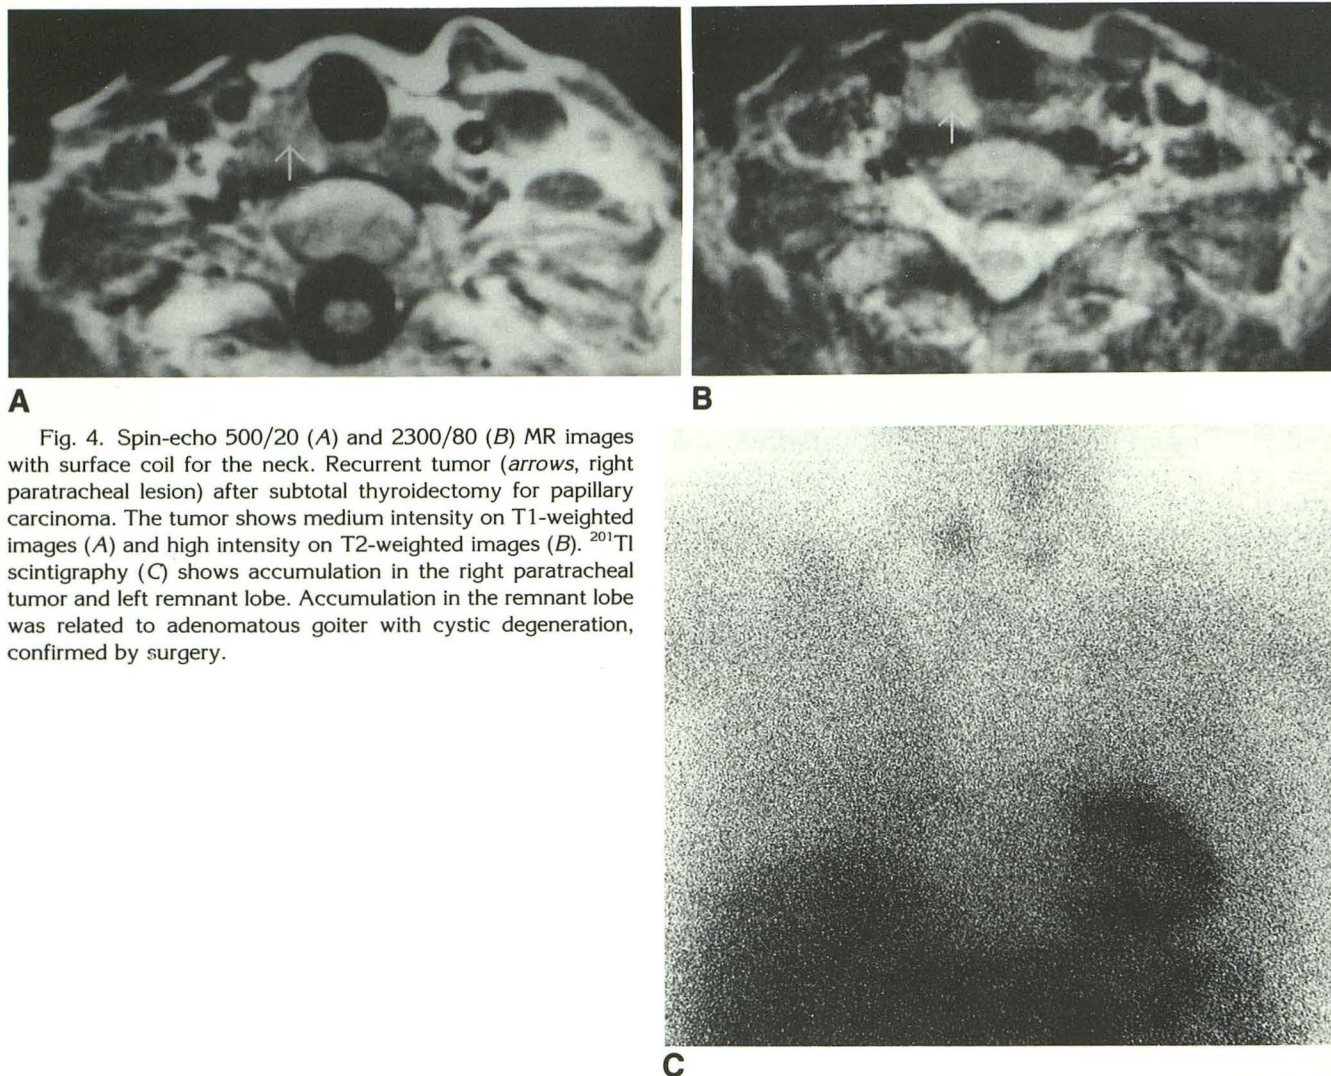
Spin-echo 500/20 (A) and 2300/80 (B) MR images with surface coil for the neck. Recurrent tumor (arrows, right paratracheal lesion) after subtotal thyroidectomy for papillary carcinoma. The tumor shows medium intensity on T1-weighted images (A) and high intensity on T2-weighted images (B). ²⁰¹Tl scintigraphy (C) shows accumulation in the right paratracheal tumor and left remnant lobe. Accumulation in the remnant lobe was related to adenomatous goiter with cystic degeneration, confirmed by surgery.
